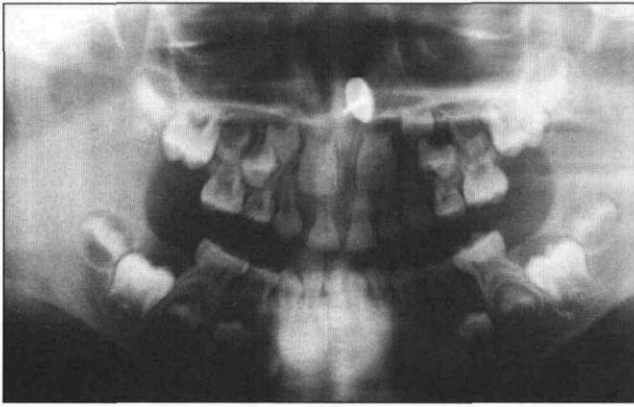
Panoramic radiograph demonstrating foreign object in nasal cavity.
